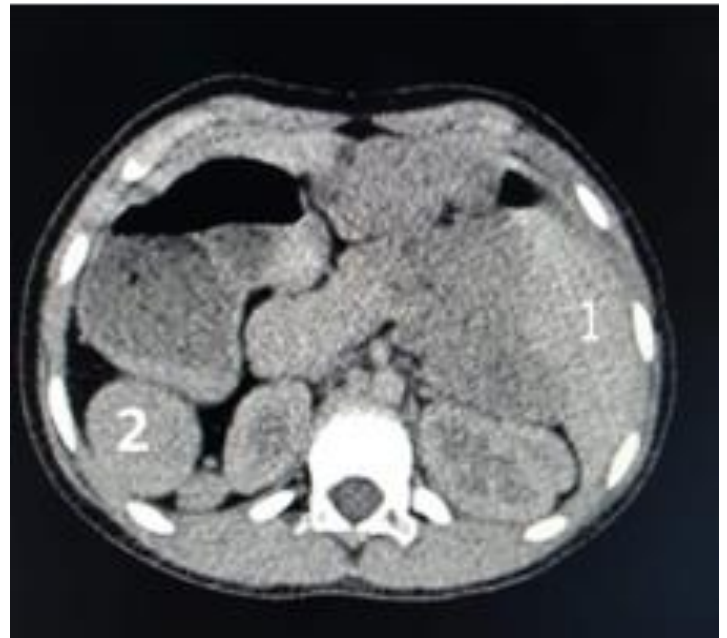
abdominal CT scan showed stomach inversion with polysplenia.
